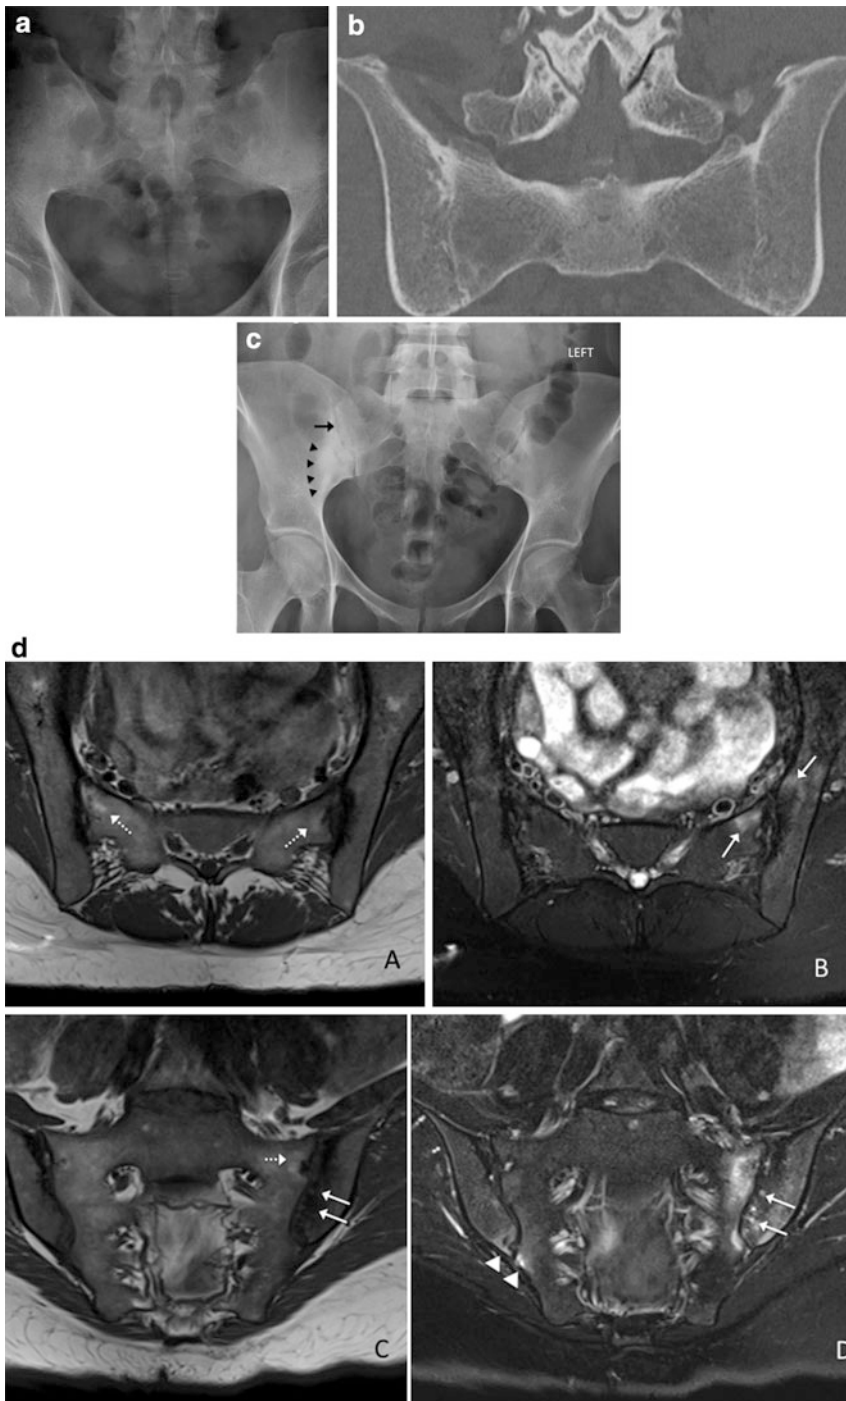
(a) There is complete ankylosis of the sacroiliac joints, in keeping with grade 4 sacroiliitis. (b) Coronal image of the CT demonstrates complete ankylosis of the sacroiliac joints, in keeping with grade 4 sacroiliitis. (c) Radiograph of the sacroiliac joints demonstrates mild sclerosis in the left sacroiliac joint with minimal erosive
